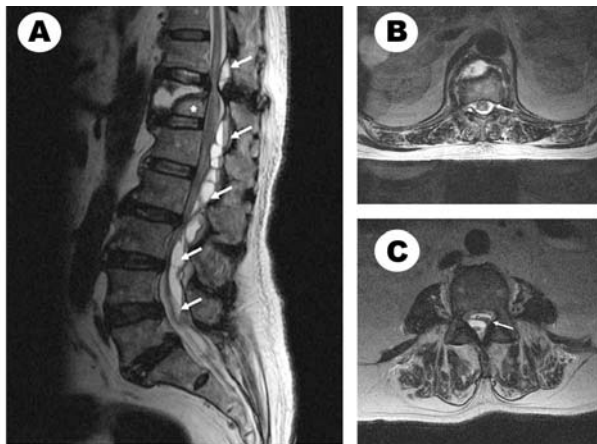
(A) T2-weighted sagittal MR image of the thoracolumbar spine shows a compression fracture at T12 (asterisk) and a huge collection of epidural hematoma (arrow) at the level of T10 to sacrum with spinal cord and cauda equina compression. The heterogeneous intensity is compatible with delayed onset of SEH which was examined at least 36 hours after symptom onset. (B) T2-weighted axial MR image of the thoracic spine at T12 level showing an epidural hematoma (arrow) with spinal cord compression and (C) the lumbar at L4 level showing an epidural hematoma (arrow) with cauda equina compression.
